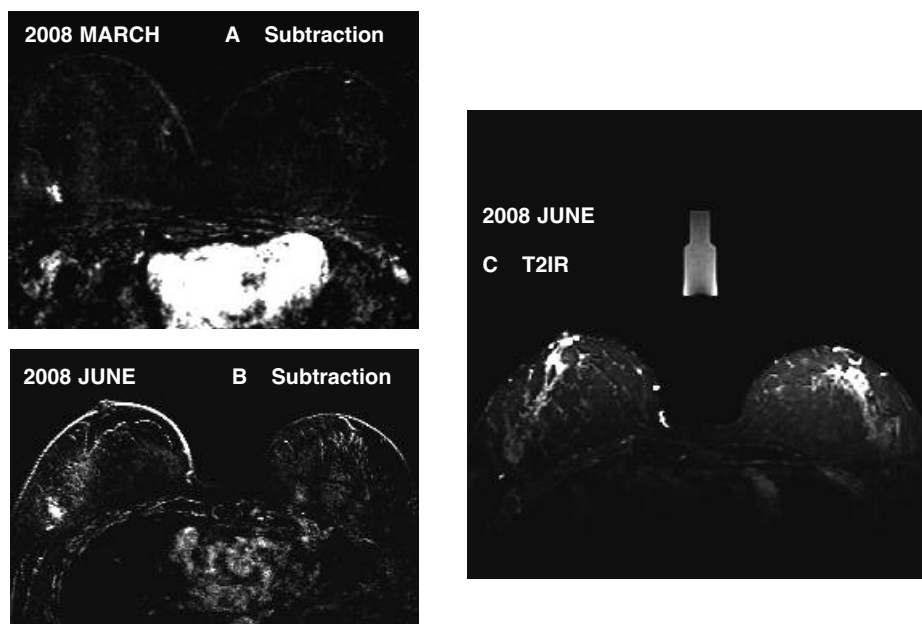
Patient no. 8. A) Subtraction imaging of March 2008, B) subtraction imaging at the recall, C) T2 IR. Sixty-three year-old patient, BRCA1 mutated. A suspected enhancement was seen in the right parenchyma at MRI (A). Despite an N1 pattern, mammography gave negative results the same day. The patient had been part of our diagnostic surveillance program for 2 years. The former MRI showed a dysplastic pattern with bilateral, small and symmetric multiple foci of enhancement. However, the cancer lesion had arisen in a region where no enhancement was detectable on previous examinations. Only 3 months later, there was an increase in the medio-lateral diameter (B), and mammography showed the onset of calcification in the same quadrant. If evaluated in a general population, the microcalcification would not be judged as suspect because of the morphology and tiny density. The lesion corresponded to a DCIS, and chemotherapy was avoided. In this case, where pure intraductal disease was found, T2 SI was only of intermediate intensity (C).
